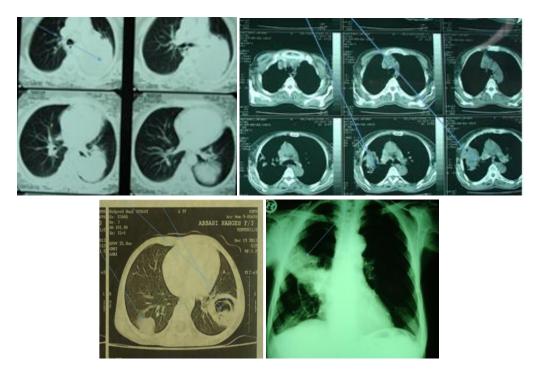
CT -scan and CXR of chest show lung collapse and mass due to hydatid cyst
